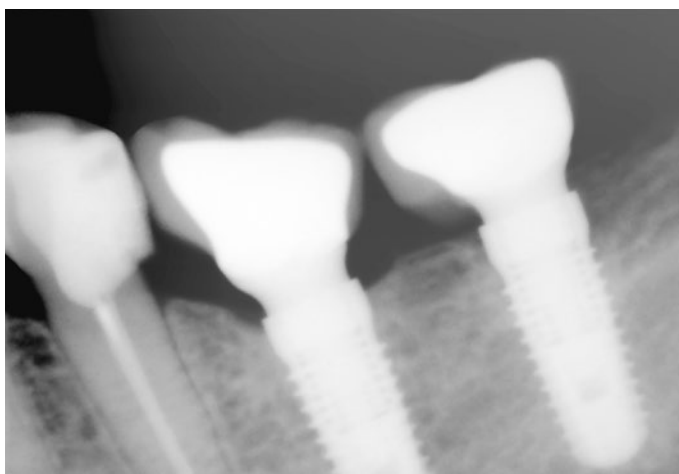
Radiograph of CAMLOG® implants with Platform-Switching, situation 5-year post-loading. Courtesy of Prof. F. Guerra
